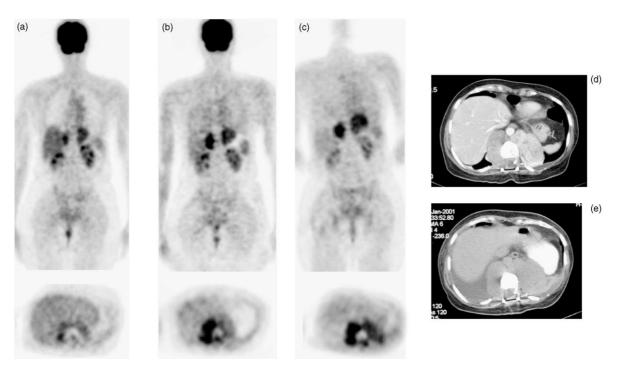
Leiomyosarcoma with a metastatic mass around the vertebral spine prior to the start of treatment on positron emission tomography (PET) (a) and computerised tomography (CT) (d). On PET at day 8 progressive disease was observed (b) and this was confirmed by PET (c) and CT (e) after 1 month of treatment.
